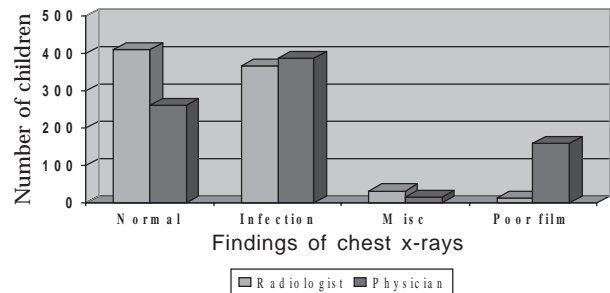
Comparison of reports of radiographs between physician and radiologist
